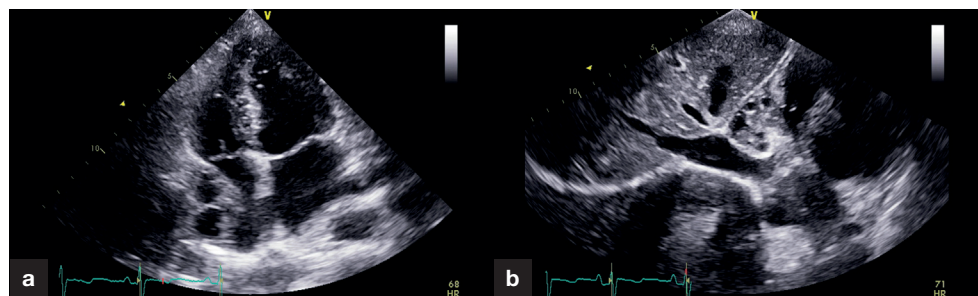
Transthoracic echo in 2019. a. Four-chamber view showing a cluster of cystic lesions compressing the right atrium. b. Subcostal view showing a cluster of cystic lesions compressing the inferior vena cava and right atrium.
